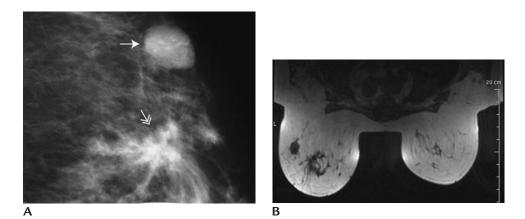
(A) Cyclosporine induced fibroadenoma. Oval mass with circumscribed margins developing in a patient on cyclosporine following cardiac transplantation. Prior mammogram (not shown) is normal. Fibroadenomas do not typically develop in postmenopausal women. Also noted is a mass with spiculated margins (*double headed arrow*) consistent with invasive ductal carcinoma not otherwise specified. (B) Magnetic resonance imaging. Pre-contrast T1-weighted axial image.
